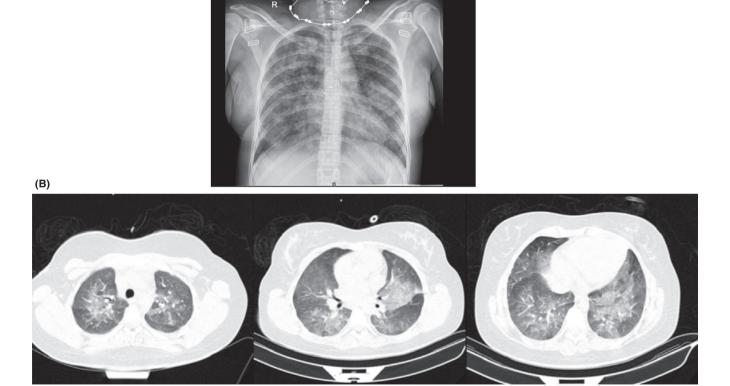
(A) Chest X-ray PA view shows multifocal parenchymal opacification. Cardiac size appears normal. (B) Axial CT scan lung window in upper, middle and lower zones of lung show diffuse bilateral ground-glass opacities in both lungs. Interlobular septal thickening and pleural effusion is not present
